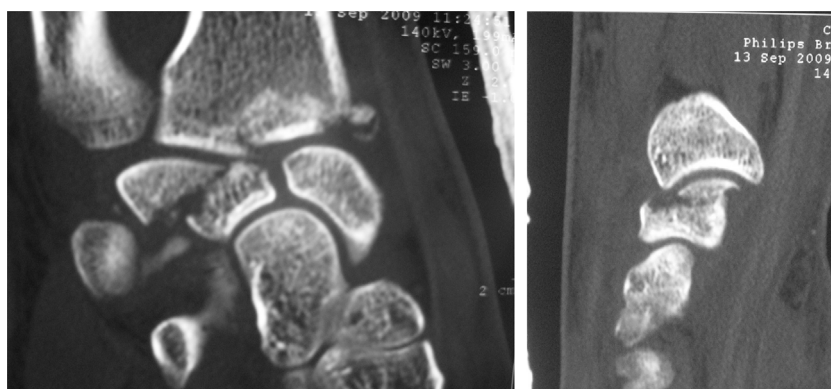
Initial CT scan with frontal and sagittal sections showing the lunate and radius fractures.
